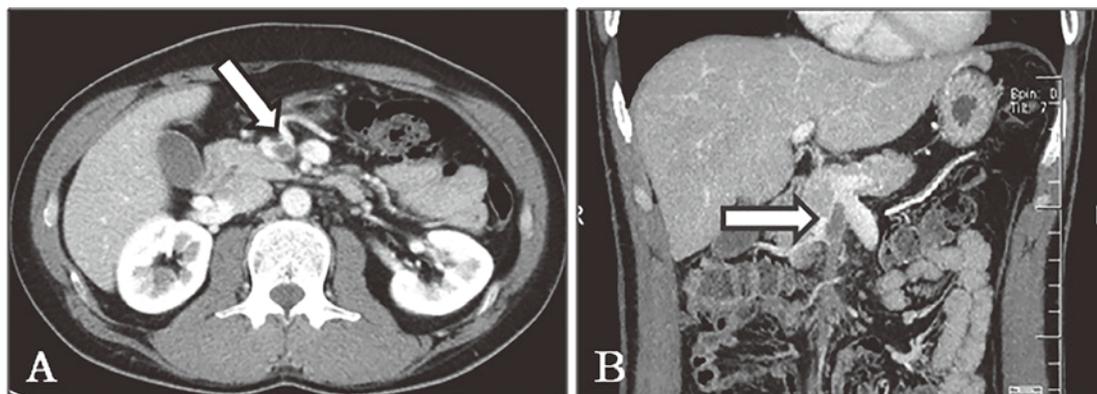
Computed tomography with contrast enhancement of the abdomen on admission. Computed tomography showed extensive thrombus formation (12 mm in diameter) in the proximal superior mesenteric vein (SMV) without ascites (arrow). Intestinal edema was not present, and intestinal blood flow was maintained.
